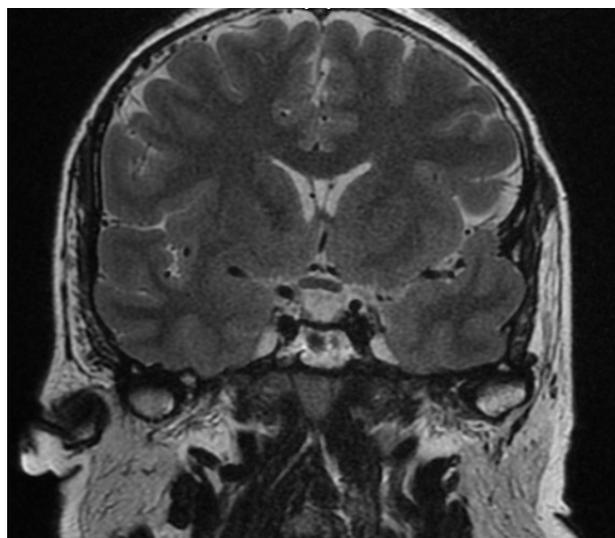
MRI of the skull of the patient in coronal plane, showing the presence of CSF at the site of the sella turcica.
